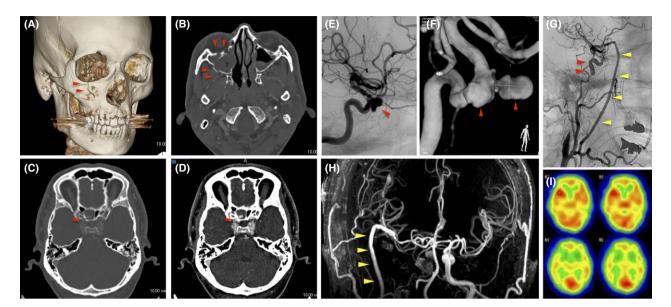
Case 2 of delayed massive epistaxis from traumatic intracranial aneurysm after blunt facial injury. A, B, Three-dimensional image and axial-slice computed tomography showing maxillary bone fracture (arrowheads). C, Axial-slice CT angiography showing the fracture line at the lateral wall of the sphenoid sinus. D, Pooling of contrast medium in the sphenoid sinus, suggesting traumatic pseudoaneurysm. E, Angiography revealing aneurysm formation on the internal carotid artery in the paraclinoid area (arrowhead). F, Three-dimensional image of aneurysm acquired by 3D-rotational angiography. G, Extracranial–intracranial bypass using radial artery graft (yellow arrowheads) and internal trapping using detachable coils (red arrowheads). H, Post-procedural magnetic resonance angiography showing collateral flow through radial artery graft (arrowheads). I, Single photon emission computed tomography at 1 month after procedures, showing no decline in cerebral blood flow.
